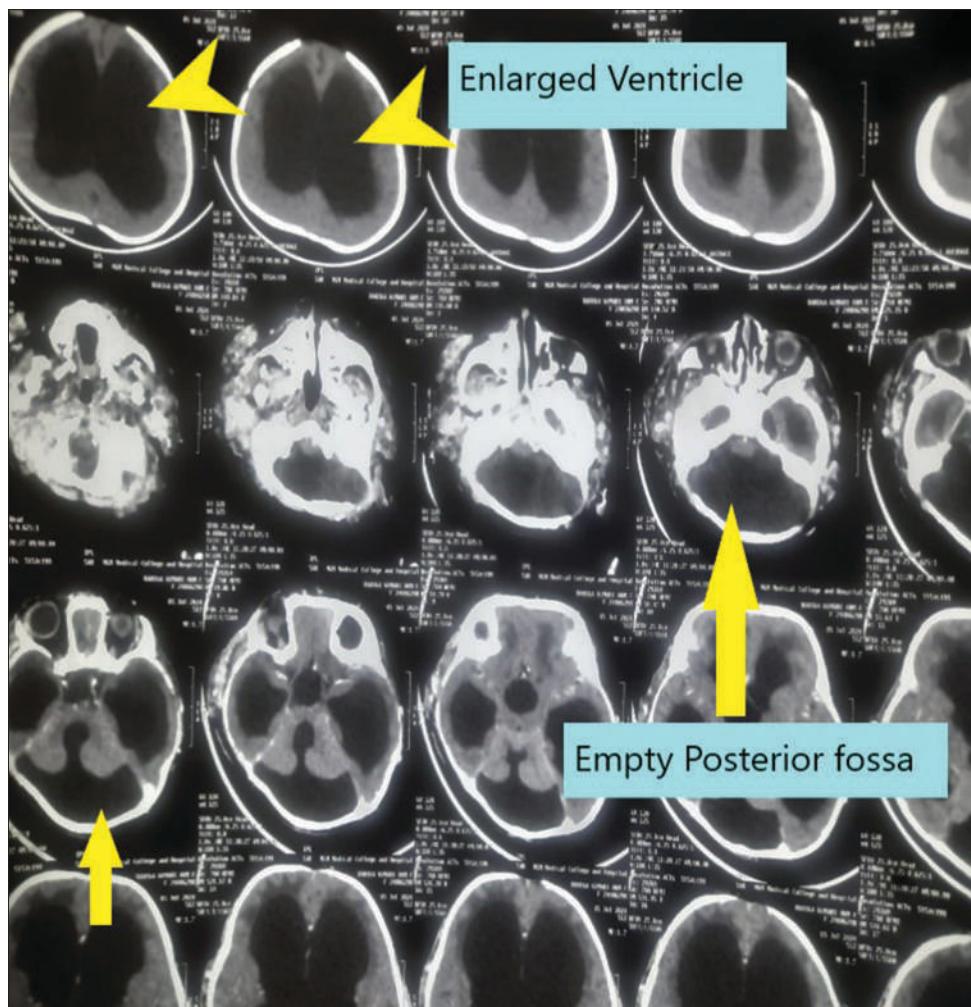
Computed tomographyangiogram showing empty postfossa along with enlarged ventricle
